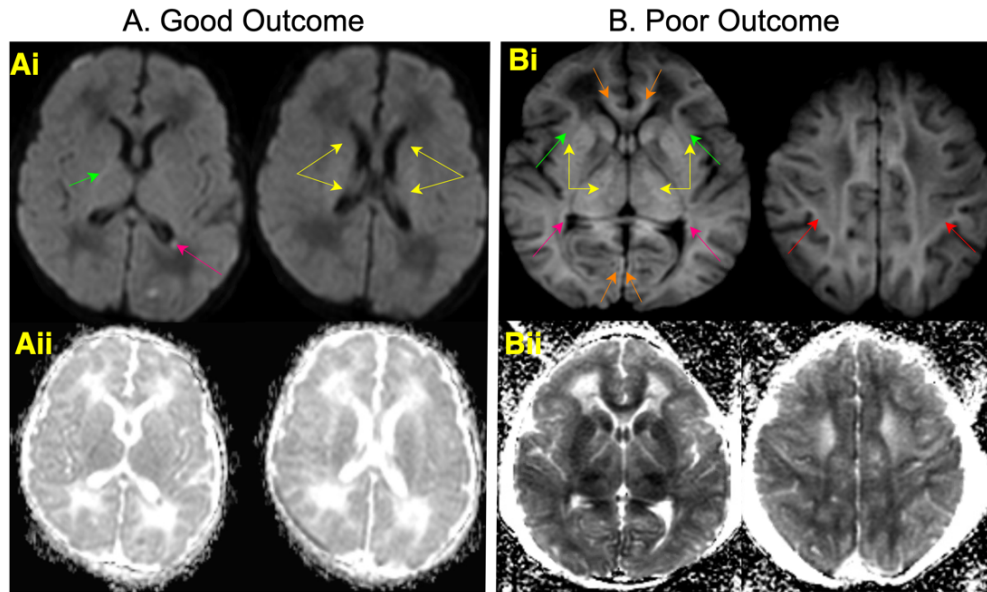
Example MRI from patients with a good outcome (A) or poor outcome (B). A. DWI-MRI of good outcome patient (same patient as Figure 3.2A). Ai. MRI injury locations are labeled in the posterior limb of internal capsule (green arrow), periventricular white matter (pink arrow), and basal ganglia and thalamus (yellow arrows). Aii. Injury pattern confirmed by ADC. Lesions appear dark in ADC and bright in DWI. B. DWI-MRI from a patient with poor outcome (same patient as Figure 3.2B). Bi. MRI injury locations in the interhemispheric fissure (orange arrows), insula (green arrows), basal ganglia and thalamus (yellow arrows), periventricular white matter (pink arrows), and central sulcus (red arrows). Bii. Injury pattern confirmed by ADC.
